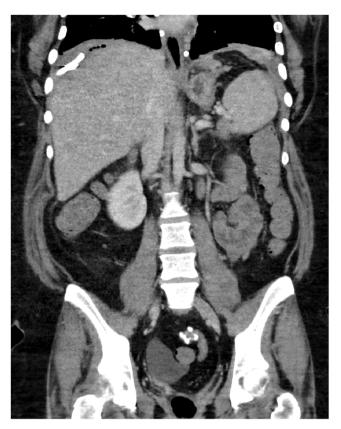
Day 60: CT Abdomen/Pelvis showed decreased size of the right and left subphrenic fluid collections.
